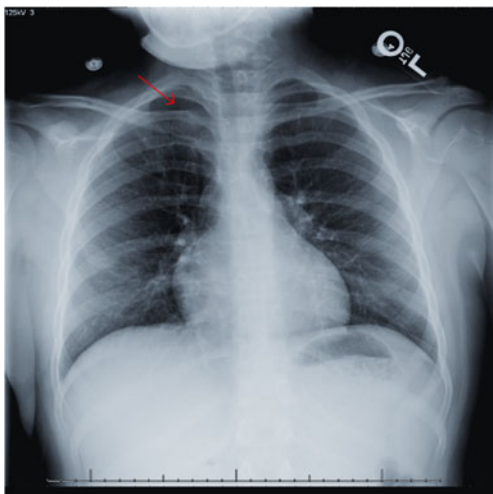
Posteroanterior chest radiograph with subtle right upper lobe consolidation labeled with arrow
